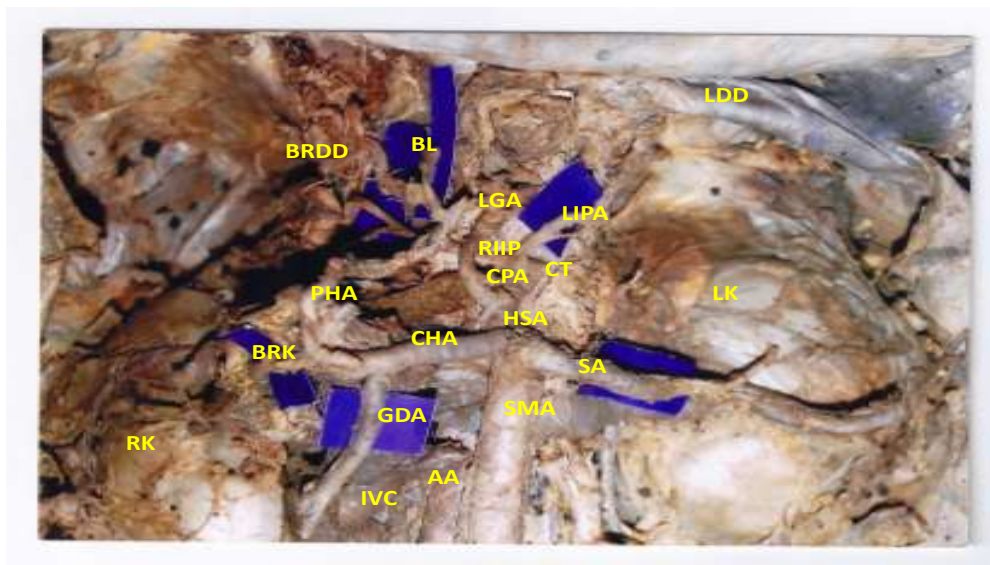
Showing the dissection of branching pattern of coeliac trunk. CT, Coeliac trunk. CPA, Common phrenic artery. LIPA, Left Inferior phrenic artery. RIPA, Right inferior phrenic artery. LGA, Left gastric artery. HSA Hepatosplenic trunk. CHA, Common hepatic or hepatic artery. SA, Splenic Artery. PHA, Proper hepatic artery. GDA, Gastro duodenal artery. BRK, Branch to right kidney. BL, branch to liver. BRDD, branch to right dome (crus) of diaphragm. AA, Abdominal aorta. Left dome (crus) of diaphragm. IVC, inferior venacava. RK, right kidney. SMA, superior mesenteric artery.
